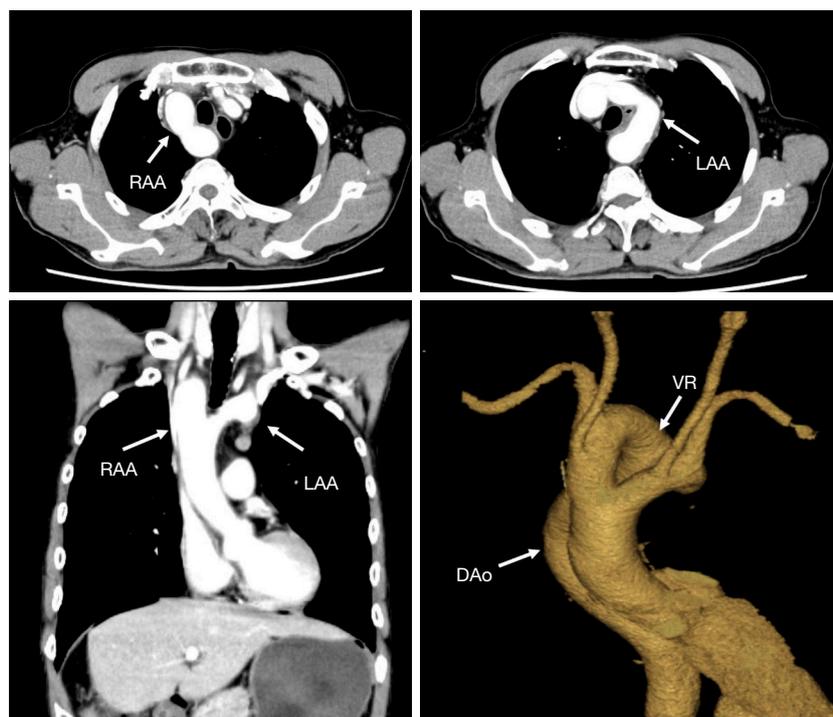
Preoperative CT shows the RAA and the LAA. Three-dimensional CT shows the double arch of aorta, VR, and DAo. CT, computed tomography; RAA, right aortic arch; LAA, left aortic arch; VR, vascular ring; DAo, descending aorta.
